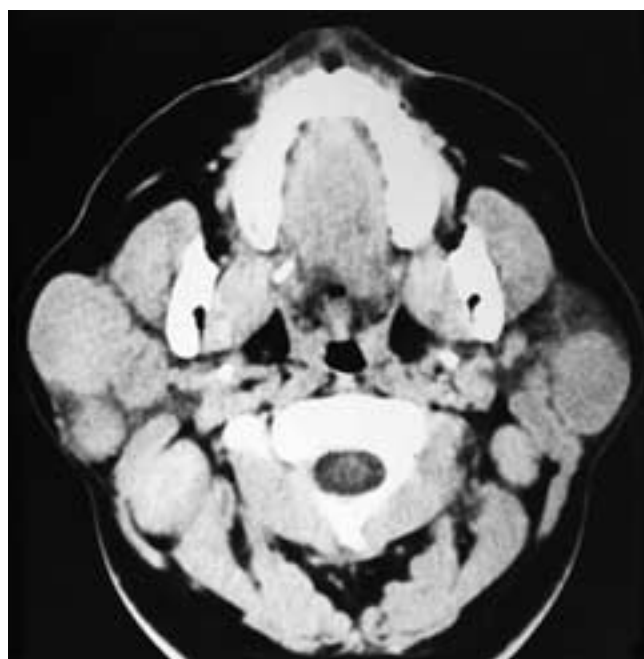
Axial CT scan shows multiple bilateral enlarged, homogeneous parotid lymph nodes. This patient had sarcoidosis.
